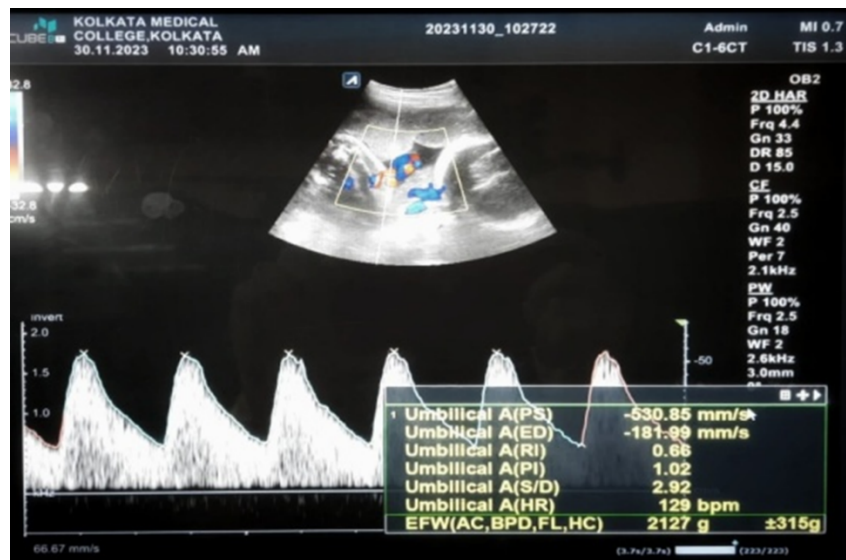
MEASUREMENT OF UMBILICAL ARTERY DOPPLER INDICES
